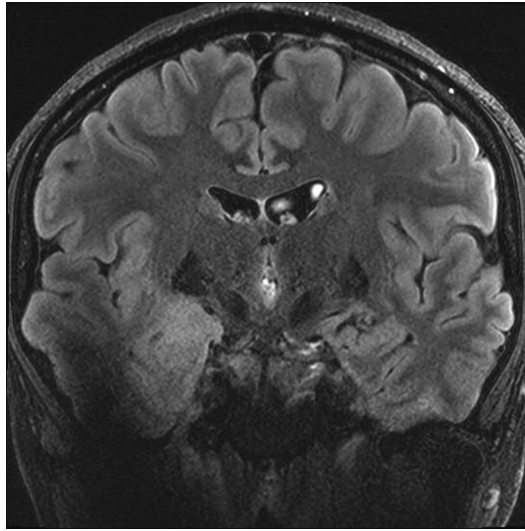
Patient with right medial temporal lobe epilepsy. Seven-Tesla MRI head T2-weighted image in the oblique-coronal plane shows right medial temporal lobe lesion that is, consistent with a low-grade glial neoplasm. Note the right temporal lobe is on the left side of the figure.
